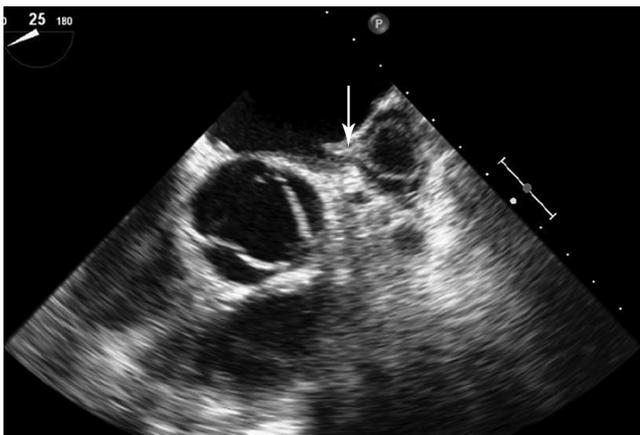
Two-dimensional transesophageal echocardiographic view of the left atrial appendage. A fresh thrombus is entrapped in the left atrial appendage, with a small portion in the left atrium (white arrow)
